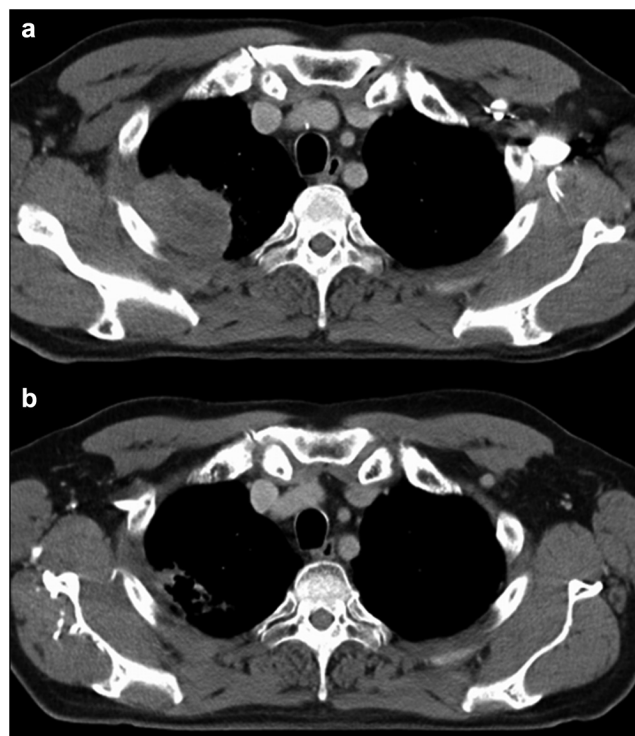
Computed tomography scan of another patient showing a sulcus superior tumor in the right upper lobe of the lung before (a) and after (b) chemoradiation.
